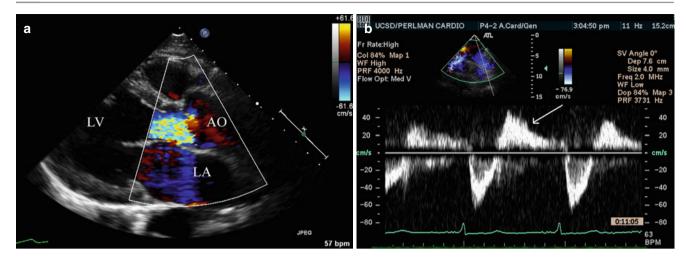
(a) Parasternal long-axis image showing a multicolored jet (indicating turbulent flow) of aortic regurgitation in the left ventricular outflow tract. The jet fills the width of the outflow tract, suggesting severe regurgitation. (b) Pulsed-wave Doppler tracing (from the suprasternal transducer position) in a case of severe aortic regurgitation.
